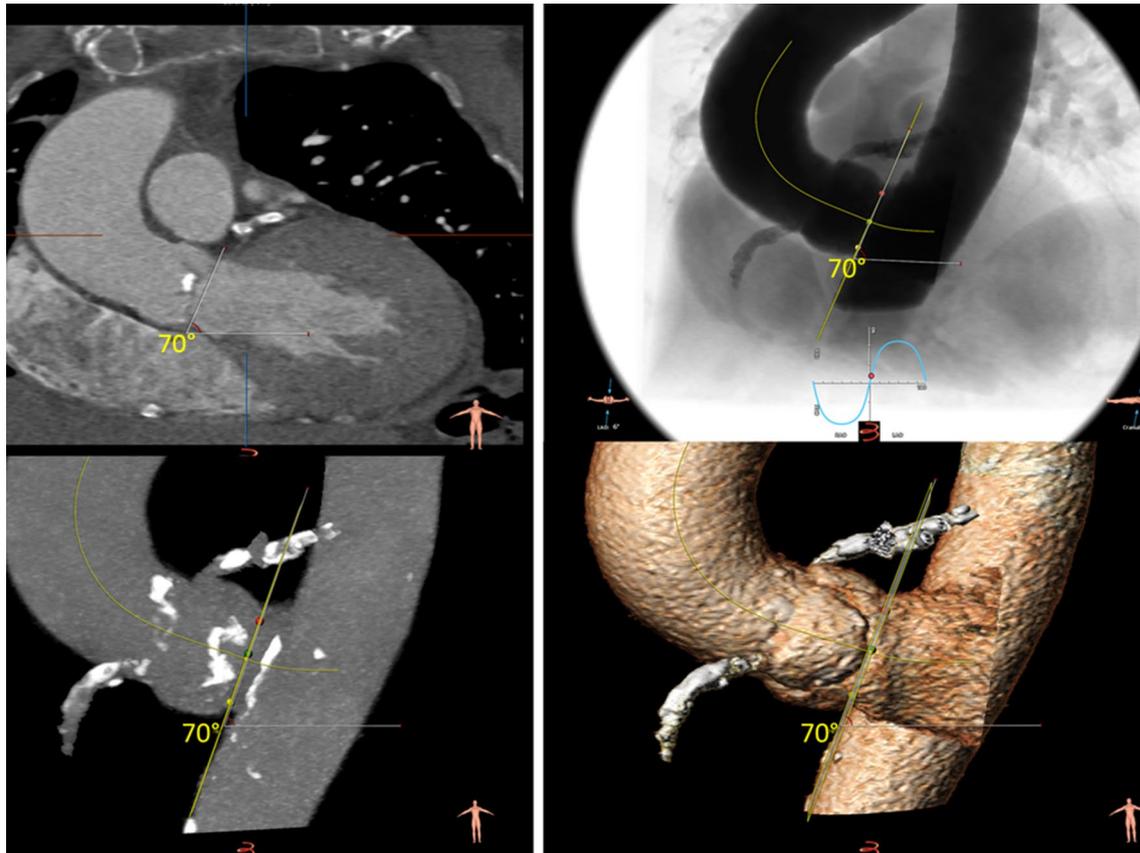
Pre-procedural CT imaging of a transcatheter aortic valve replacement candidate with an aortic angle of 70° (CT coronal multiplanar reconstruction, angiographic nadir view, calcifications enhanced view, 3-D reconstruction)
